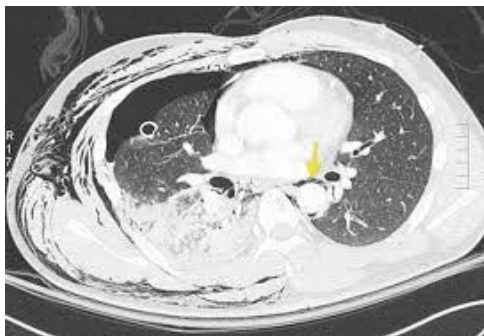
CT scan. Massive subcutaneous emphysema of upper thorax after lung surgery; also pneumothorax and pneumomediastinum is associated.
